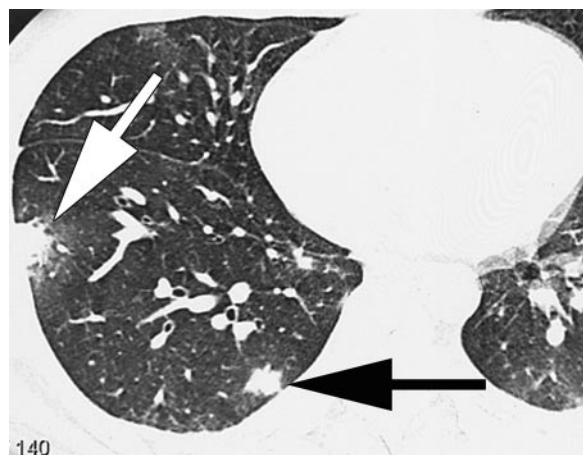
C sinensis* infestation in a 25-year-old man. A skin test for *C sinensis* was strongly positive, and *Clonorchis*-specific IgG antibody by enzyme-linked immunosorbent assay was 0.27 (normal range, 0–0.25). Transverse thin-section (1-mm collimation) CT scan (lung windowing) shows multiple airspace nodules with surrounding ground-glass opacity in both lungs (arrows).
